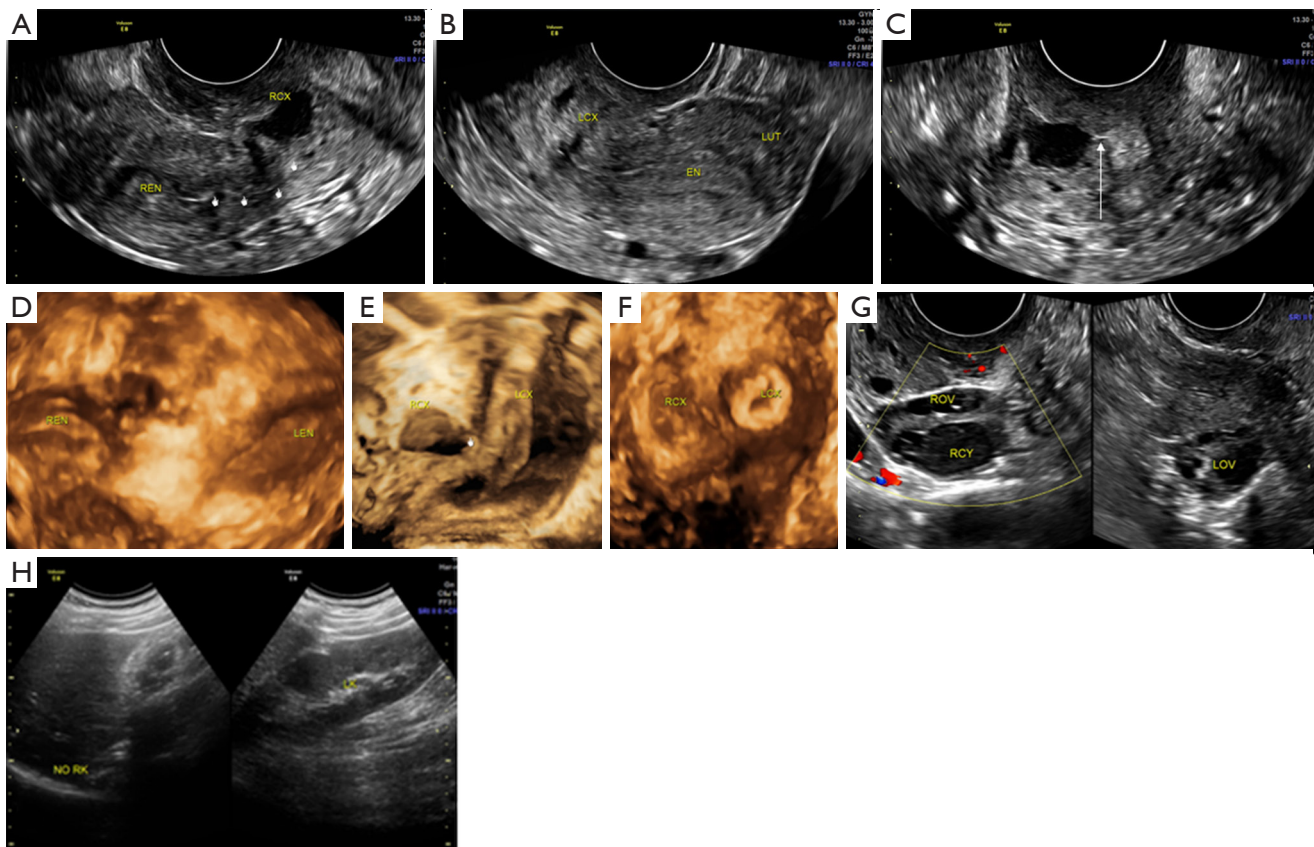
Type IV UGTOIRA syndrome: U3b-C3c-V0, complete bicorporal uterus, double cervix (partial cervical fusion) with right cervical canal effusion and obliterated external cervical orifice, with a normal vagina, with a fistula on the cervical fusion, endometrial cyst of the right ovary, and right renal agenesis. Sonograms were obtained from a 22-year-old female patient. (A) TVS 2D right uterine sagittal plane demonstrating a normal uterus, cervix with cervical canal effusion, and atresia of the external orifice (the hand arrows indicate that the cervical canal effusion continues with the uterine cavity). (B) TVS 2D left uterine sagittal plane demonstrating a normal uterus and cervix. (C) TVS 2D cross-section of the fused part of the double cervix (the arrow indicates the communication between the cervical canals on both sides). (D) TVS 3D coronal plane of the uterus under stereoscopy demonstrating a complete bicorporal uterus. (E) TVS 3D coronal plane of the cervix under stereoscopy demonstrating that the upper parts of the 2 cervixes are separated and that the lower parts of the 2 cervixes are fused, with the sinus visible in the fusion part (the hand arrow indicates the sinus). (F) TAS 3D cross-section of the fused part of the double cervix. (G) TAS 2D ovarian sagittal planes demonstrating an endometriosis cyst within the right ovary (left side of the figure) and a normal left ovary (right side of the figure). (H) TAS 2D sagittal planes identifying the absence of the right kidney (NO RK; left side of the figure) and a normal left kidney (LK; right side of the figure). REN, right endometrium; RCX, right cervix; LCX, left cervix; EN, endometrium; LUT, left uterus; LEN, left endometrium; ROV, right ovary; RCY, right ovarian cyst; LOV, left ovary; RK, right kidney; UGTOIRA, unilateral genital tract obstruction with ipsilateral renal anomaly; TVS, transvaginal sonography; 2D, 2-dimensional; 3D, 3-dimensional; TAS, transabdominal sonography.
